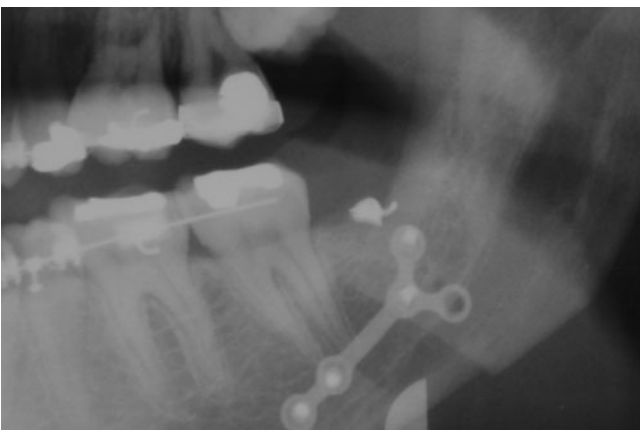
MP orthopantomogram
